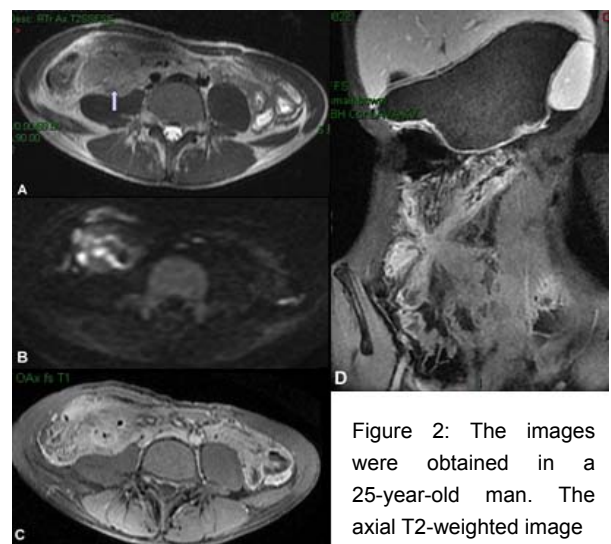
The images were obtained in a 25-year-old man. The axial T2-weighted image
